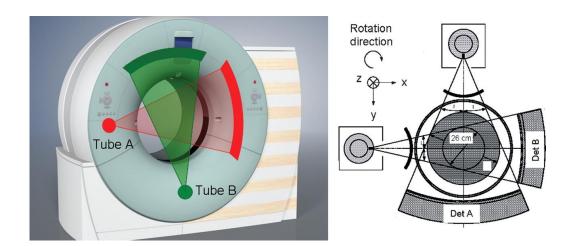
show the Definition Dual Source CT scanner and its tube-detector configuration.
